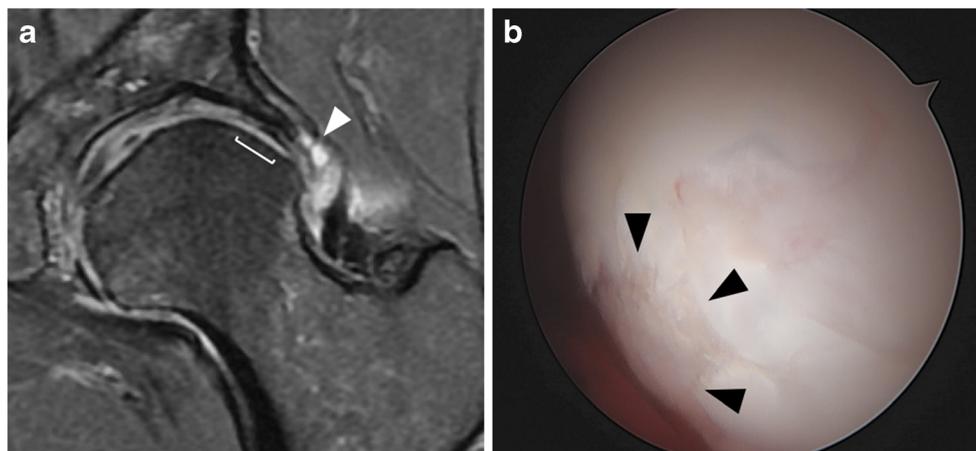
Full-thickness defect of the superior lateral femoral head. Hip MRI (coronal 2D T2 fat-suppressed FSE) of a 53-year-old female patient with advanced degeneration of the left hip. The labrum was torn with associated paralabral cysts (a, white arrowhead). Moreover, the patient
